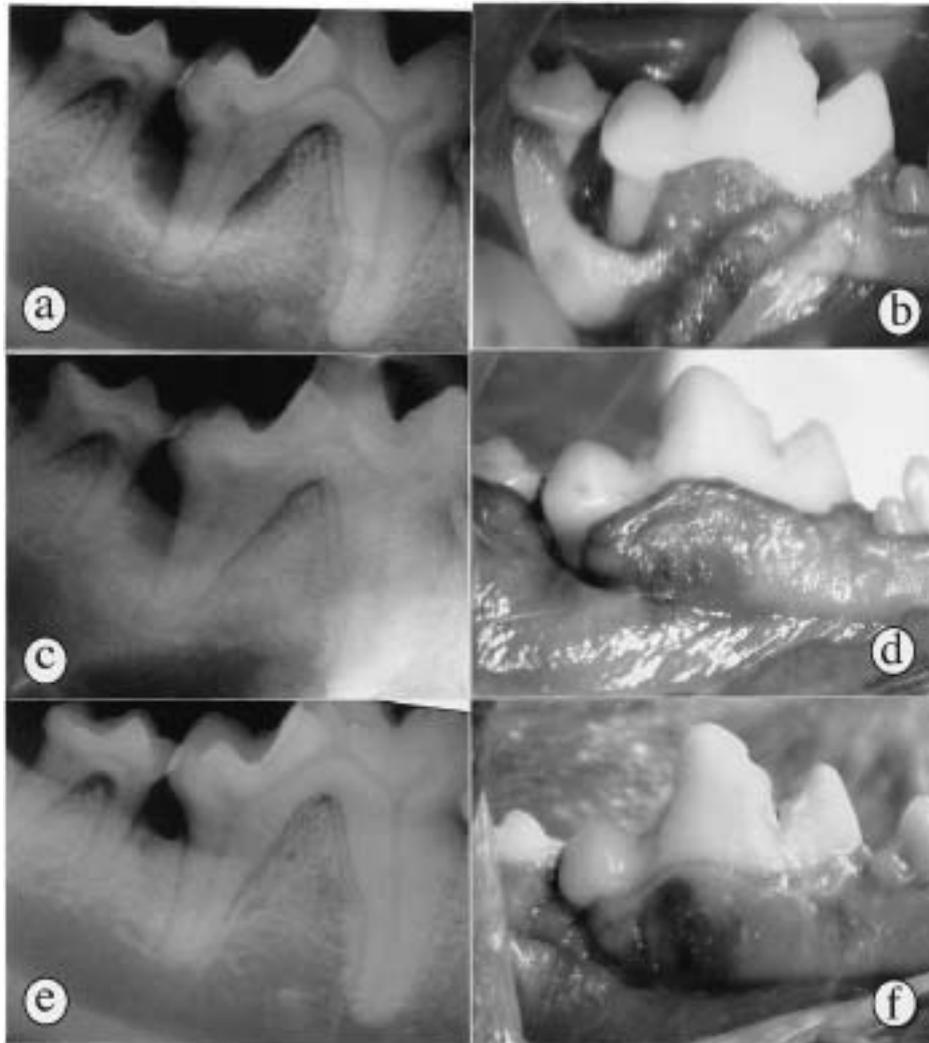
Dental radiographs and the clinical findings in case 2. (a): Radiograph taken preoperatively. (b): Clinical view of a vertical resorption of bone in operation. (c): Radiograph at 1 month postoperatively. (d): Clinical view of the gingiva at 1 month postoperatively. (e): Radiograph at 8 months postoperatively. (f): Clinical view of the gingiva at 8 months postoperatively.
